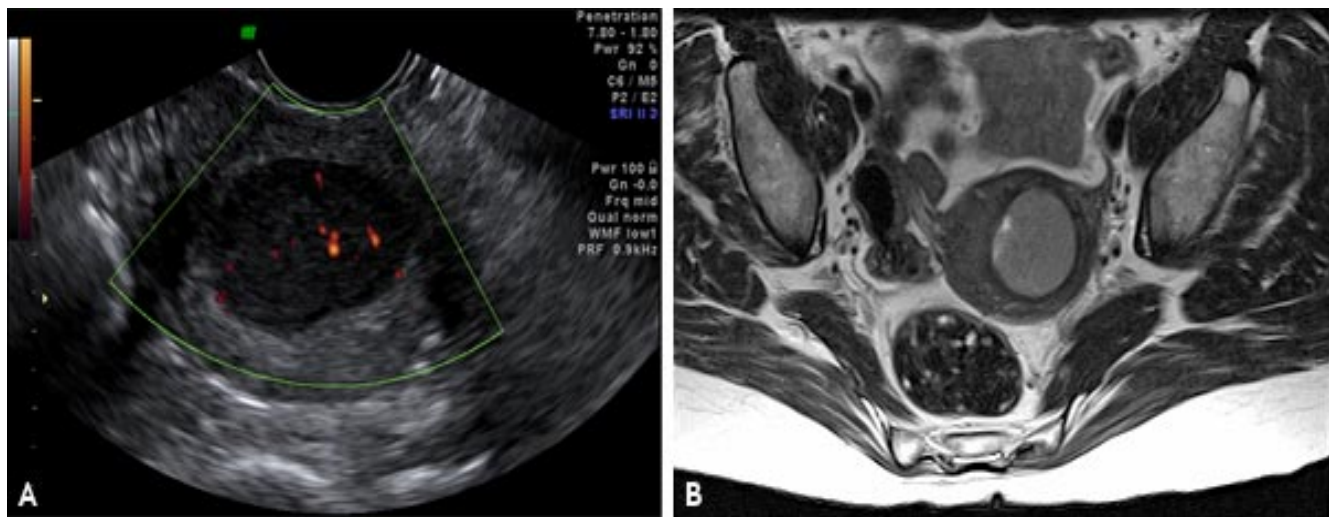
A, Axial ultrasound image of the uterine fundus shows a well-circumscribed, homogeneously hypoechoic mass with increased through-transmission. Doppler interrogation shows internal vascularity (orange areas).
